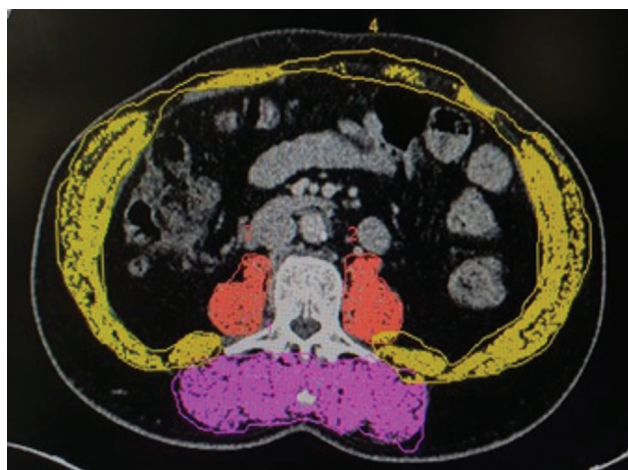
Computed tomography (CT) image of a 50-year-old male who had vague abdominal pain. Image depicts utilization of segmentation technique in CT for calculating skeletal mass index at L3 level. In this case, the skeletal mass index was 60 cm²/m² (>52.4 cm²/m² cut-off), suggesting that there is no sarcopenia.
